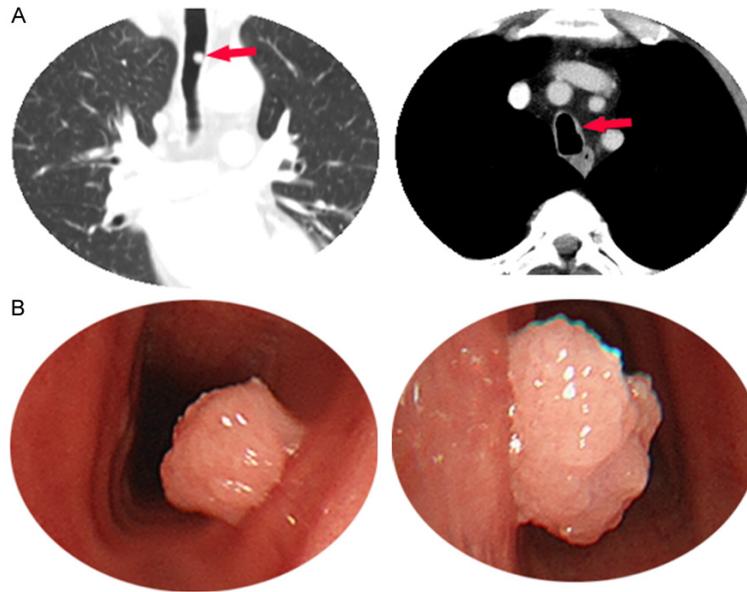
Imaging and flexible bronchofiberscope findings in the case. A. Chest computed tomography (CT) shows a 2 × 2-cm nodule in the middle of the trachea (arrow). B. A cauliflower like neoplasm is located at about 4cm away from subglottis of the trachea.
